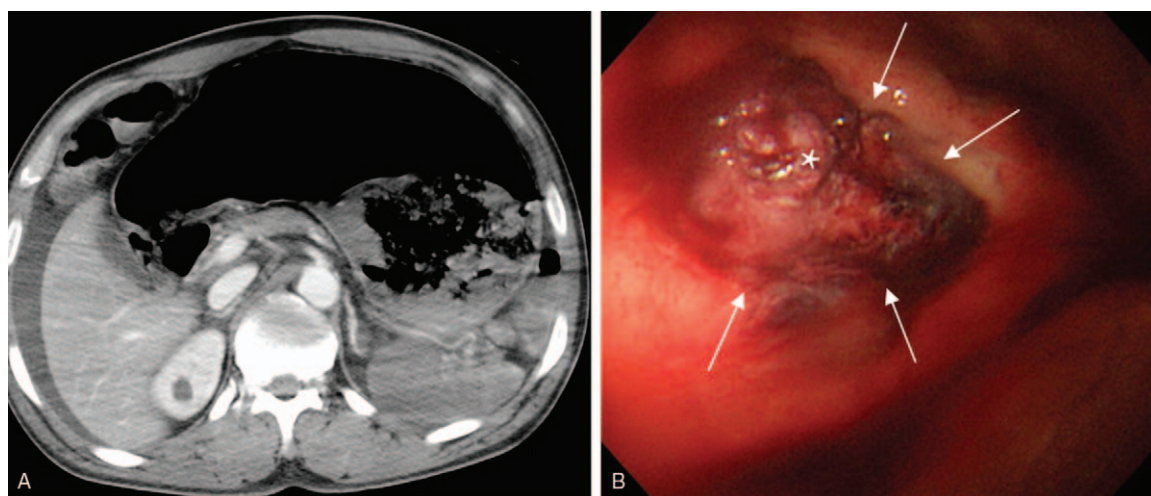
(A) Portal phase contrast-enhanced CT scan showing hematoma filled stomach and decreased enhancement of the spleen. (B) Upper GI endoscopy showing a huge ulcer (arrows) and an exposed vessel (asterisk) in the posterior wall of gastric high body. CT=computed tomography, GI=gastrointestinal.
